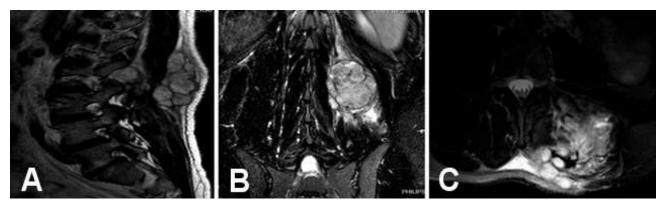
A; Contrast-enhanced T2-weighted sagittal lumbar vertebra MRI taken at the third month postoperatively. Recurrent mass lesion image showing multilobular heterogeneous contrast enhancement localized posterior to L2-L4 vertebral corpuscles. B; Postoperative contrast-enhanced T2 weighted coronal lumbar vertebra MRI section. The image of a recurrent mass in the left paravertebral muscle tissue. C; Postoperative contrast-enhanced T2 weighted axial lumbar vertebra MRI section showing a localized, multilobular expansile mass lesion at the previous operation site.
